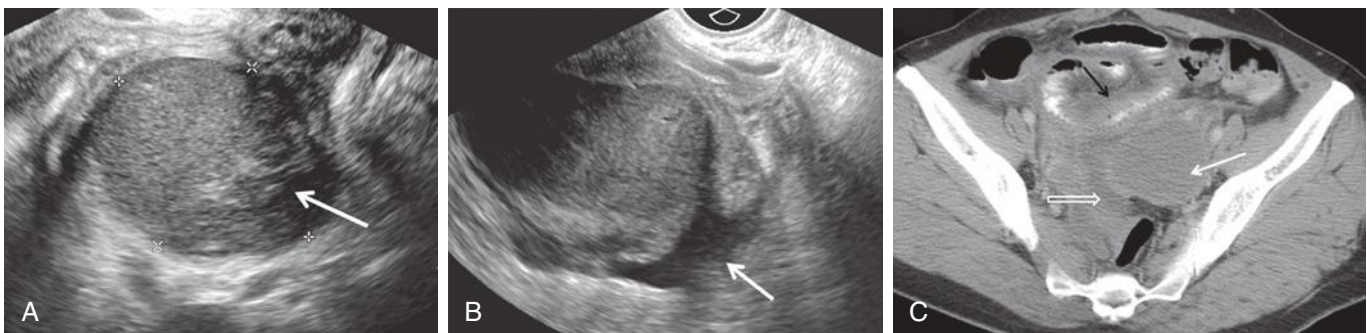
Ruptured endometrioma in a patient with acute onset of left lower quadrant pain A, Complex mass (*calipers*) with internal echoes and echogenic focus compatible with clot (*arrow*). B, There is associated free fluid (*arrow*) containing echoes, most consistent with hemoperitoneum. C, Computed tomography shows the endometrioma (*solid white arrow*). There is a small amount of free fluid (*open arrow*) and pelvic inflammatory changes. There is reactive thickening of an adjacent loop of small bowel (*black arrow*). Ruptured endometrioma was confirmed at surgery.
